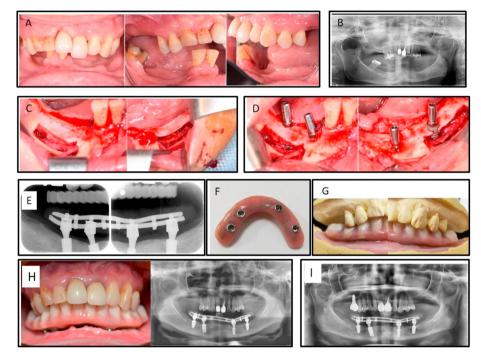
Clinical and radiographic photographs of our patient. (A) Pre-operation intraoral condition. Ridge was resorbed equal or below the floor of mouth. (B) Pre-operation panoramic radiograph showing that mental foramens were located at the first premolar areas. (C) Inferior alveolar nerve repositioning and hollowing of the mandible. (D) Poor paralleling of implants. Tooth 36 implant body exposure was also noted. (E) Conometric coping was precisely fitted to conometric abutment. (F) Tissue surface of the denture. (G) Conometric denture: the first molar occlusion was prefabricated. (H) Intraoral condition and panoramic radiograph after fixed conometric denture delivery. (I) One-year follow-up. No periodontal defect was noted around the implants.
